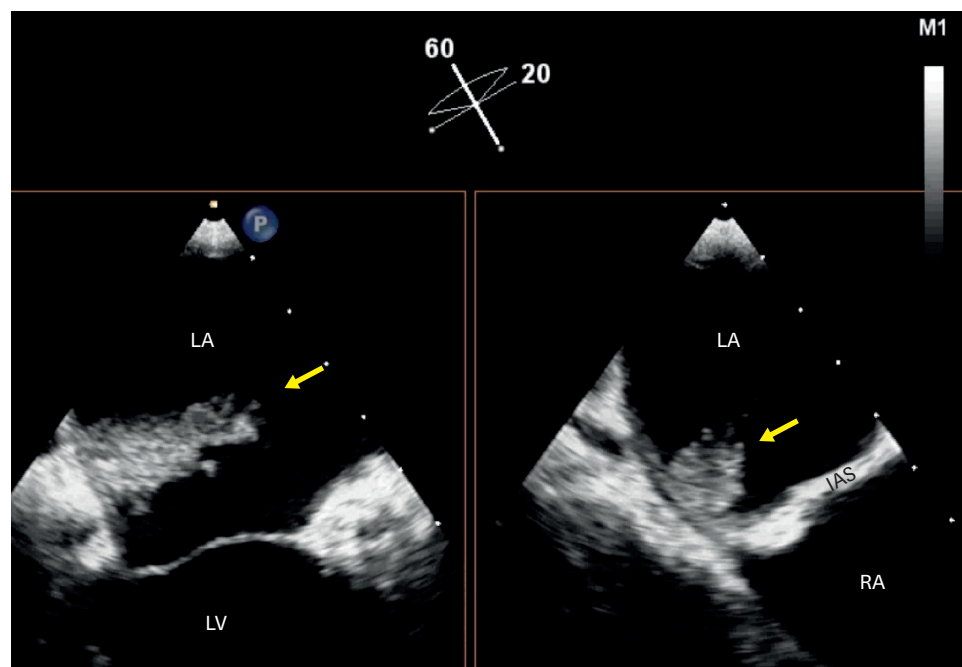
Transesophageal echocardiogram (two chamber view) showing the LA with a friable and very mobile mass just above the mitral annulus on the left, and on the right image with 90° rotation, showing its location at the transition between the LA posterior wall and interatrial septum. IAS: inter-atrium septum, LA: left atrium, LV: left ventricle, RA: right atrium.
